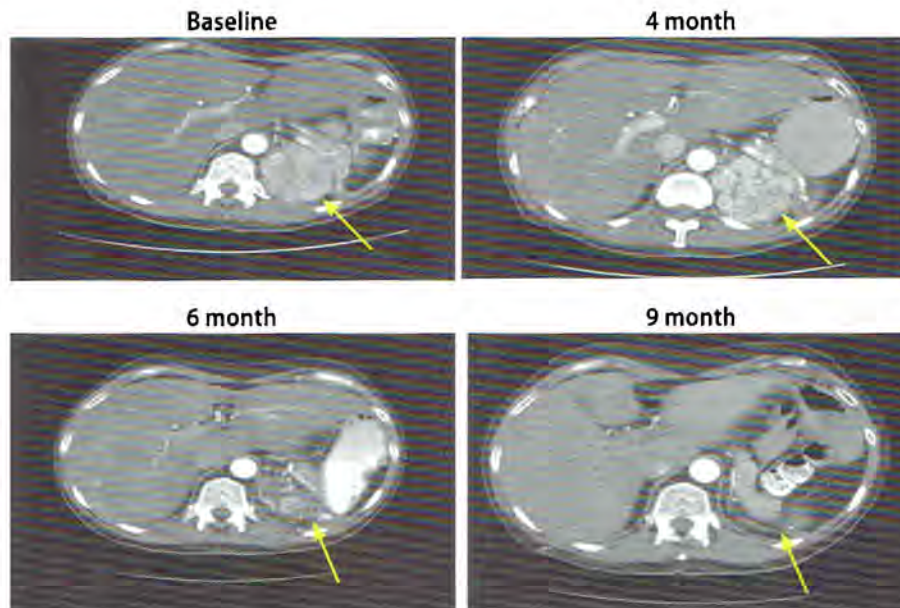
CT scans showing tumor response to sunitinib treatment in a patient with local recurrence of RCC (scans courtesy of M. Dror Michaelson, MD, PhD, Massachusetts General Hospital Cancer Center, Boston, MA)
